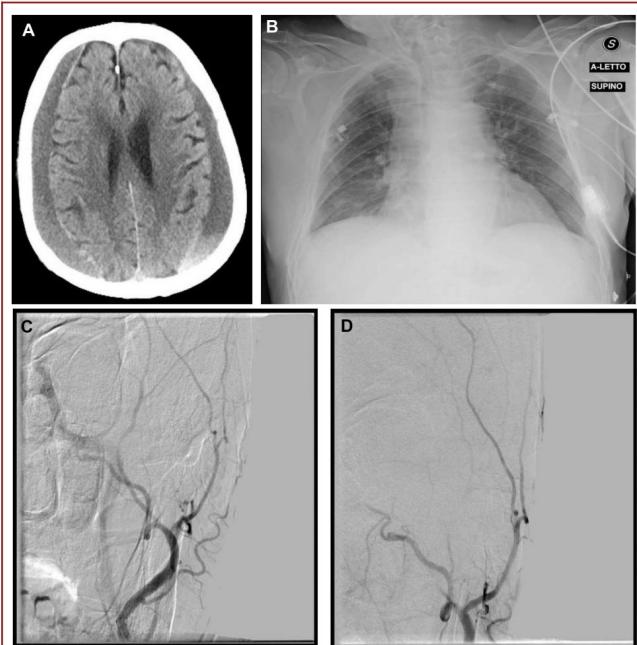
A. Head CT scan, axial view: bilateral CSDH. B. CXR showing bilateral and diffuse IP. C and D, MMA embolization procedure.
